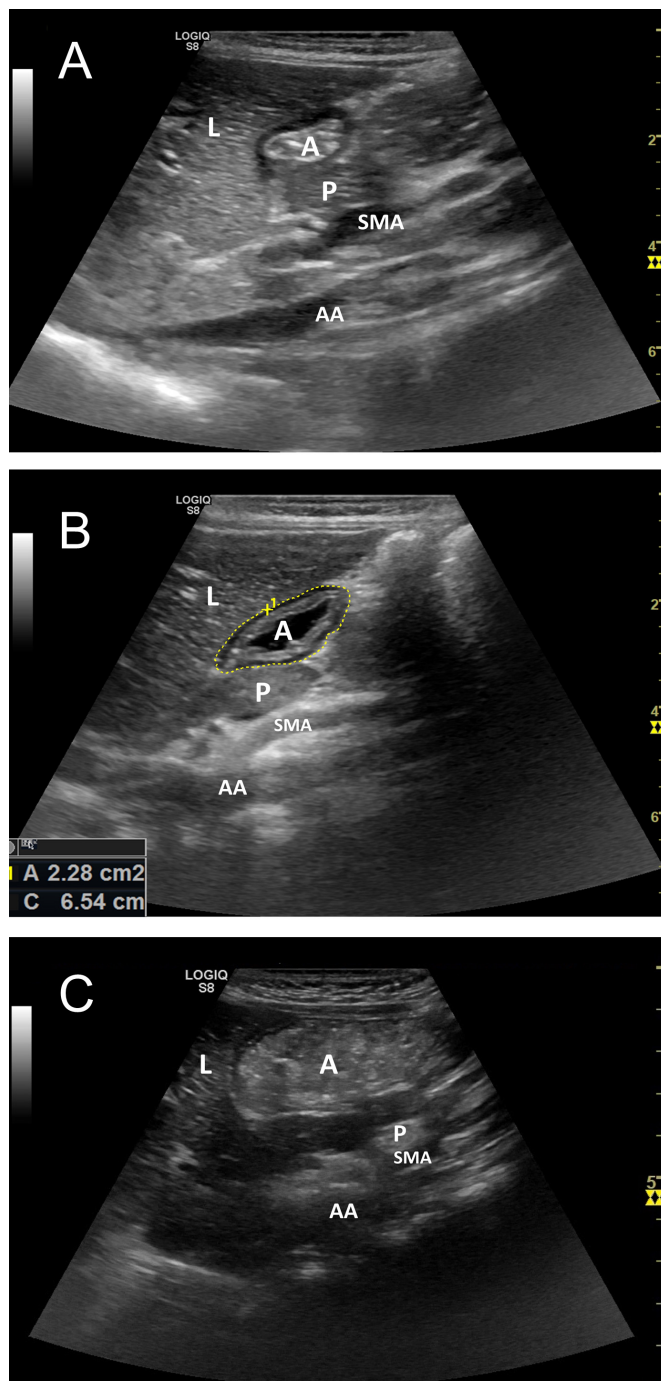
Interpretation of ultrasound images. Gastric contents were assessed as empty (A), liquid (B), and solid (C). Cross-sectional area (CSA) of the antrum can be evaluated by tracing the circumference of the antrum following the serosal layer (yellow dotted line). The gastric volume can be estimated from the CSA and age by using the following equation: Gastric Volume (mL/kg) = $-7.8 + (3.5 \times \text{CSA (cm}^2\text{)}) + (0.127) \times \text{Age (months)}$ = $-7.8 + (3.5 \times 2.28) + (0.127 \times 16)$ = 1.2 mL/kg. L, liver; A, antrum of the stomach; P, pancreas; SMA, superior mesenteric artery; AA, abdominal aorta.
